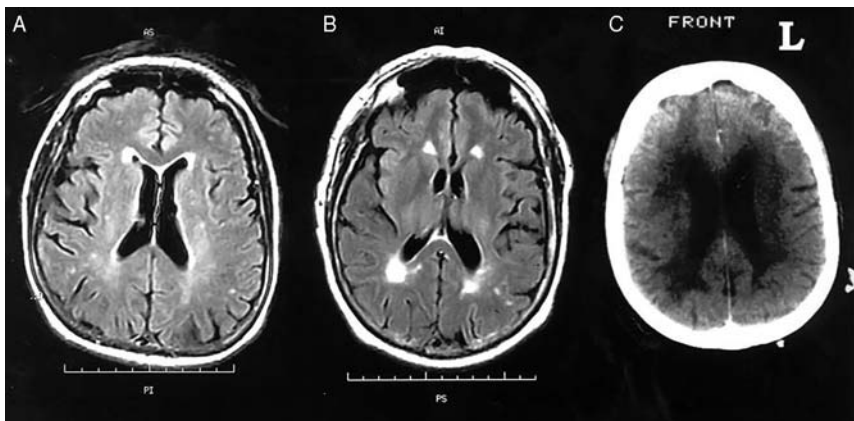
Subcortical white matter hyperintensities, seen on FLAIR (transaxial) MRI brain scan, which demonstrates mild (A) and somewhat more advanced (B) periventricular findings. On noncontrast CT brain scan (C), there is prominent hypodensity in the periventricular region. These findings have been referred to as Binswanger's disease in the past, but more recently the term leukoariosis has been preferred because of the nonspecific clinical correlates of such findings.
